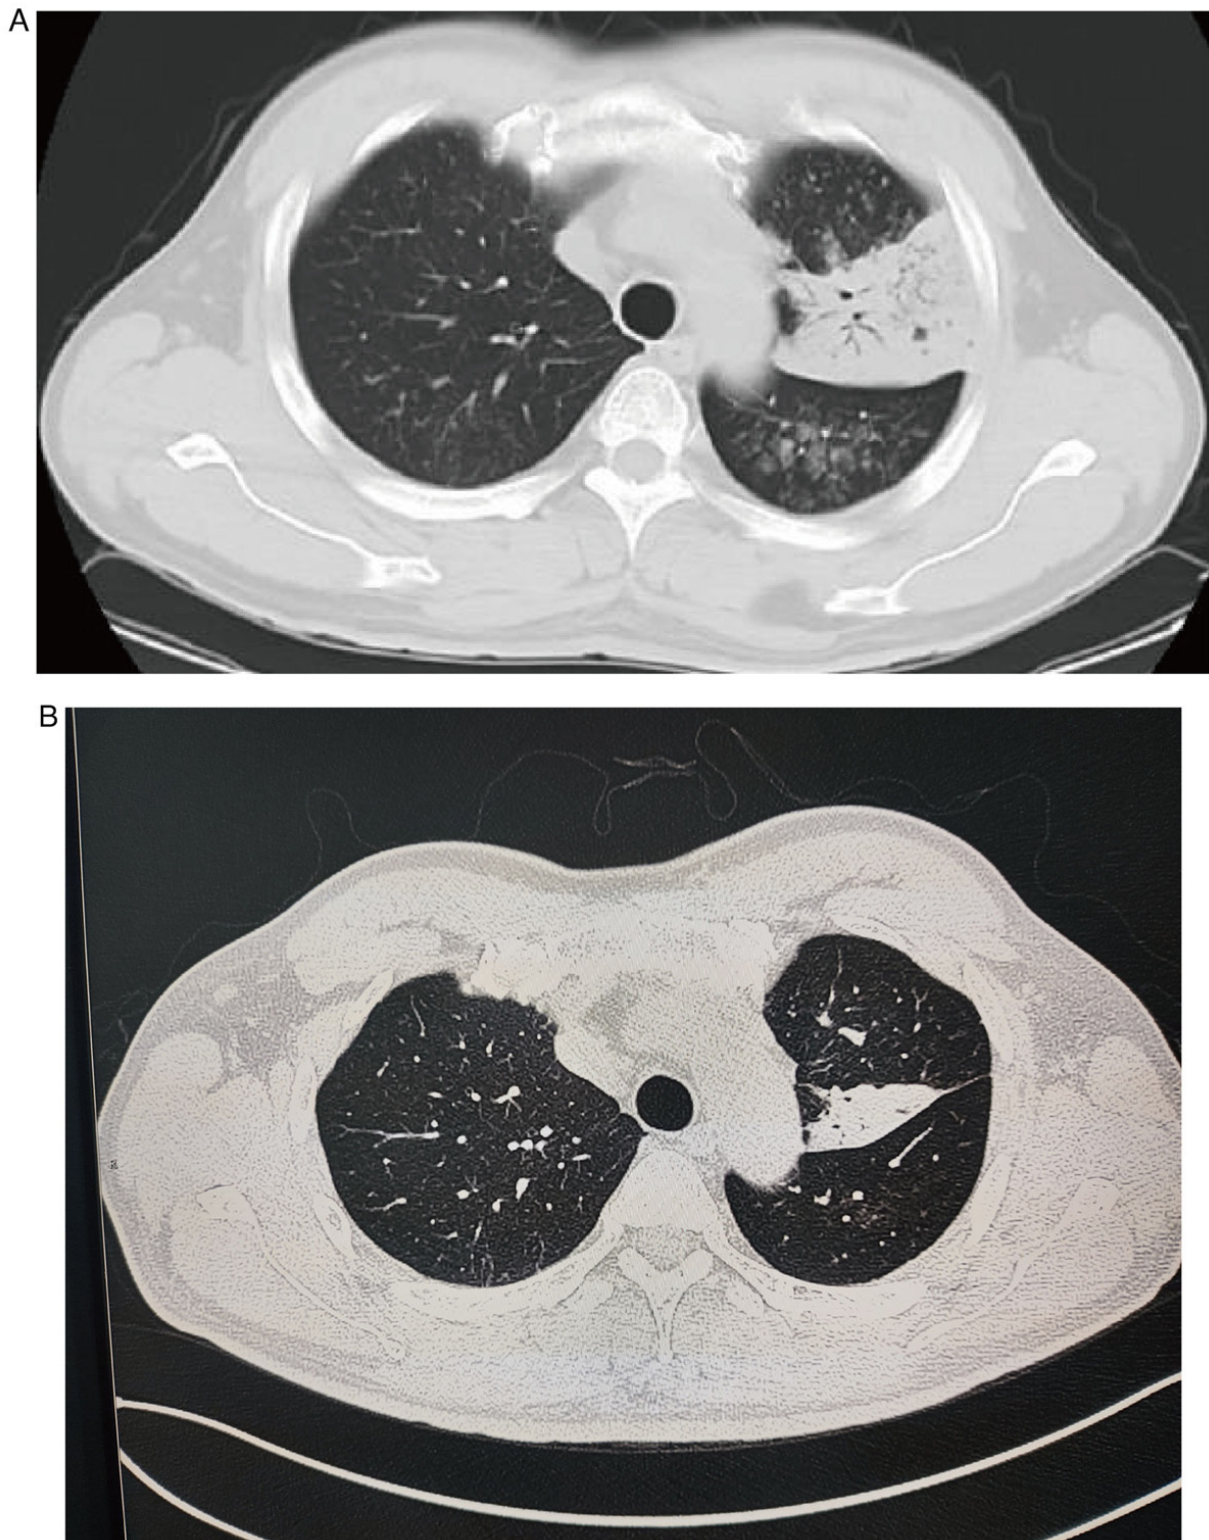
Comparison of CT results (A) before and (B) after 2 months of treatment with oxitinib + bevacizumab, demonstrating significant reduction of the lesion.
